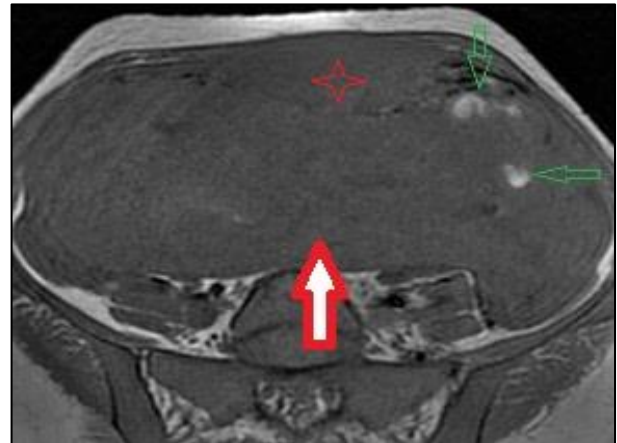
Axial T1 weighted sequence MRI identifying the mass (arrow), merging form the posterior wall of the uterus (star), with visible foci of hemorrhage (green arrows).
